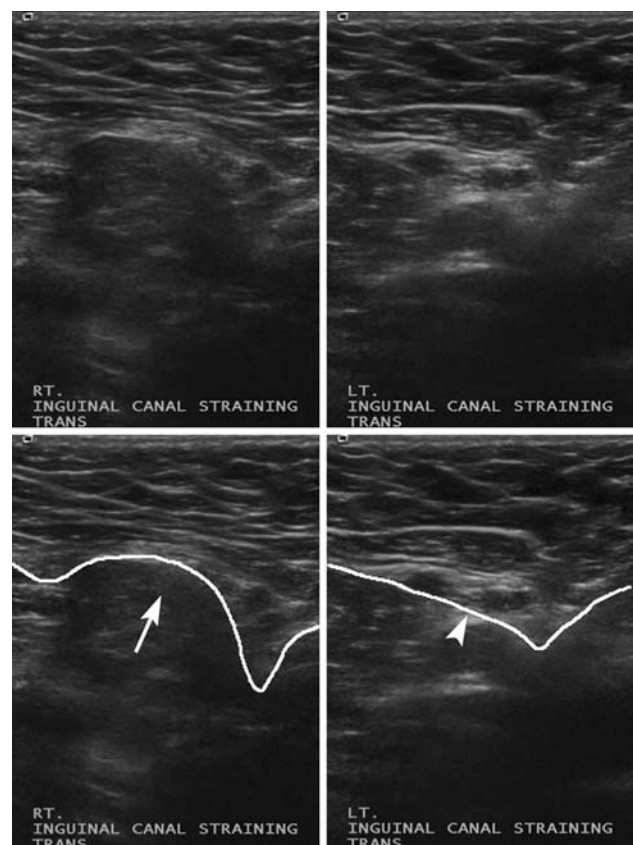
Ultrasound of right-sided sports hernia. The imaging plane is transverse to the long axis of the inguinal canal, with the patient’s head to the left of the image. The assessment is performed in real-time as the patient strains (e.g. during a shallow sit-up or when asked to ‘tense’ the abdominal muscles). The contour of each posterior inguinal wall is indicated by a superimposed *white line*. The sports hernia is appreciated as a mild anterior bulge of the posterior inguinal wall on the right side of the patient (*arrow*). The normal left posterior inguinal wall is straight (*arrowhead*). A video clip showing the real-time dynamics of sports hernia can be found on YouTube (searching under ‘sports hernia’) or at the author’s website (<http://www.sportsmedicineimaging.com>)
